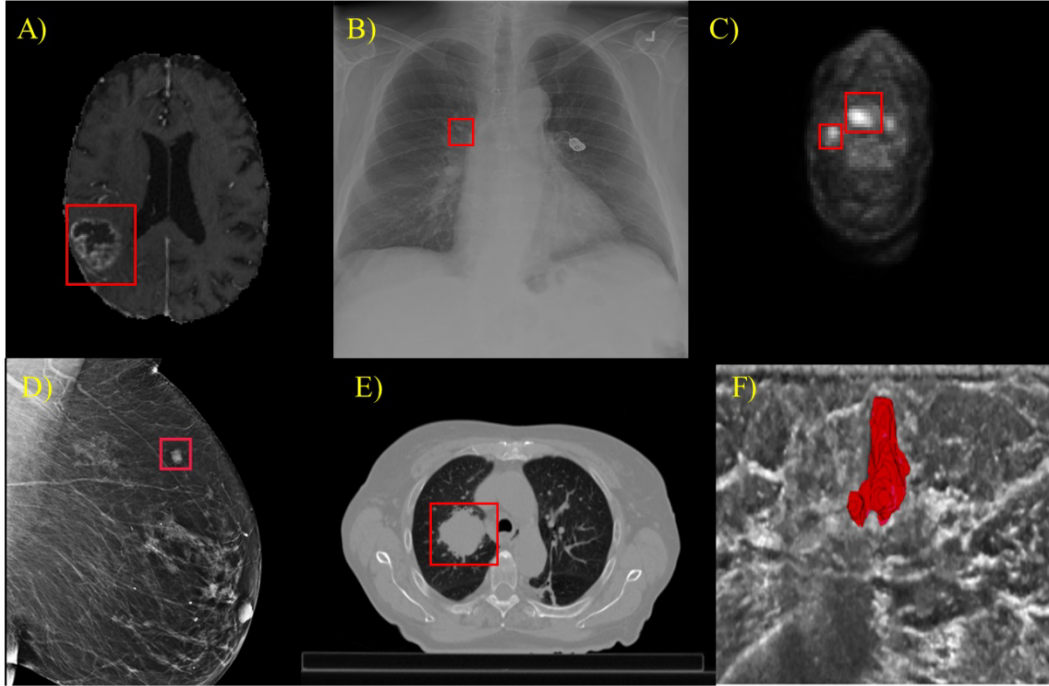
Different imaging modalities are used for screening different types of tumors. A) imaging glioblastoma with MRI modality; B) lung cancer detection in chest X-ray; C) imaging head-neck tumor with PET, i.e., nuclear medicine modality; D) breast cancer detection in digital mammography; E) lung cancer screening with CT imaging; and F) breast tumor segmentation in 3D ultrasound images.
